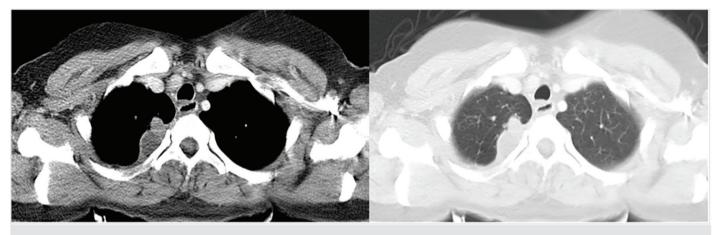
Axial thoracic CT showing a cystic lesion in the right apical thoracic wall, abutting ribs *CT: Computed tomography*
